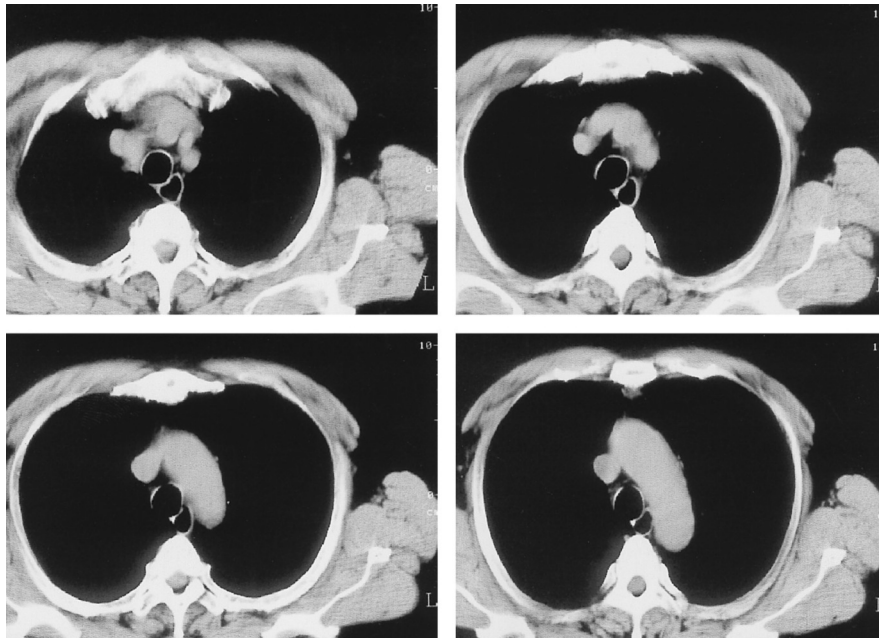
This is a CT scan taken 2 years before the patient's recent presentation. This scan was taken when the patient was brought to our hospital because of a traffic accident. There was no abnormal finding.
